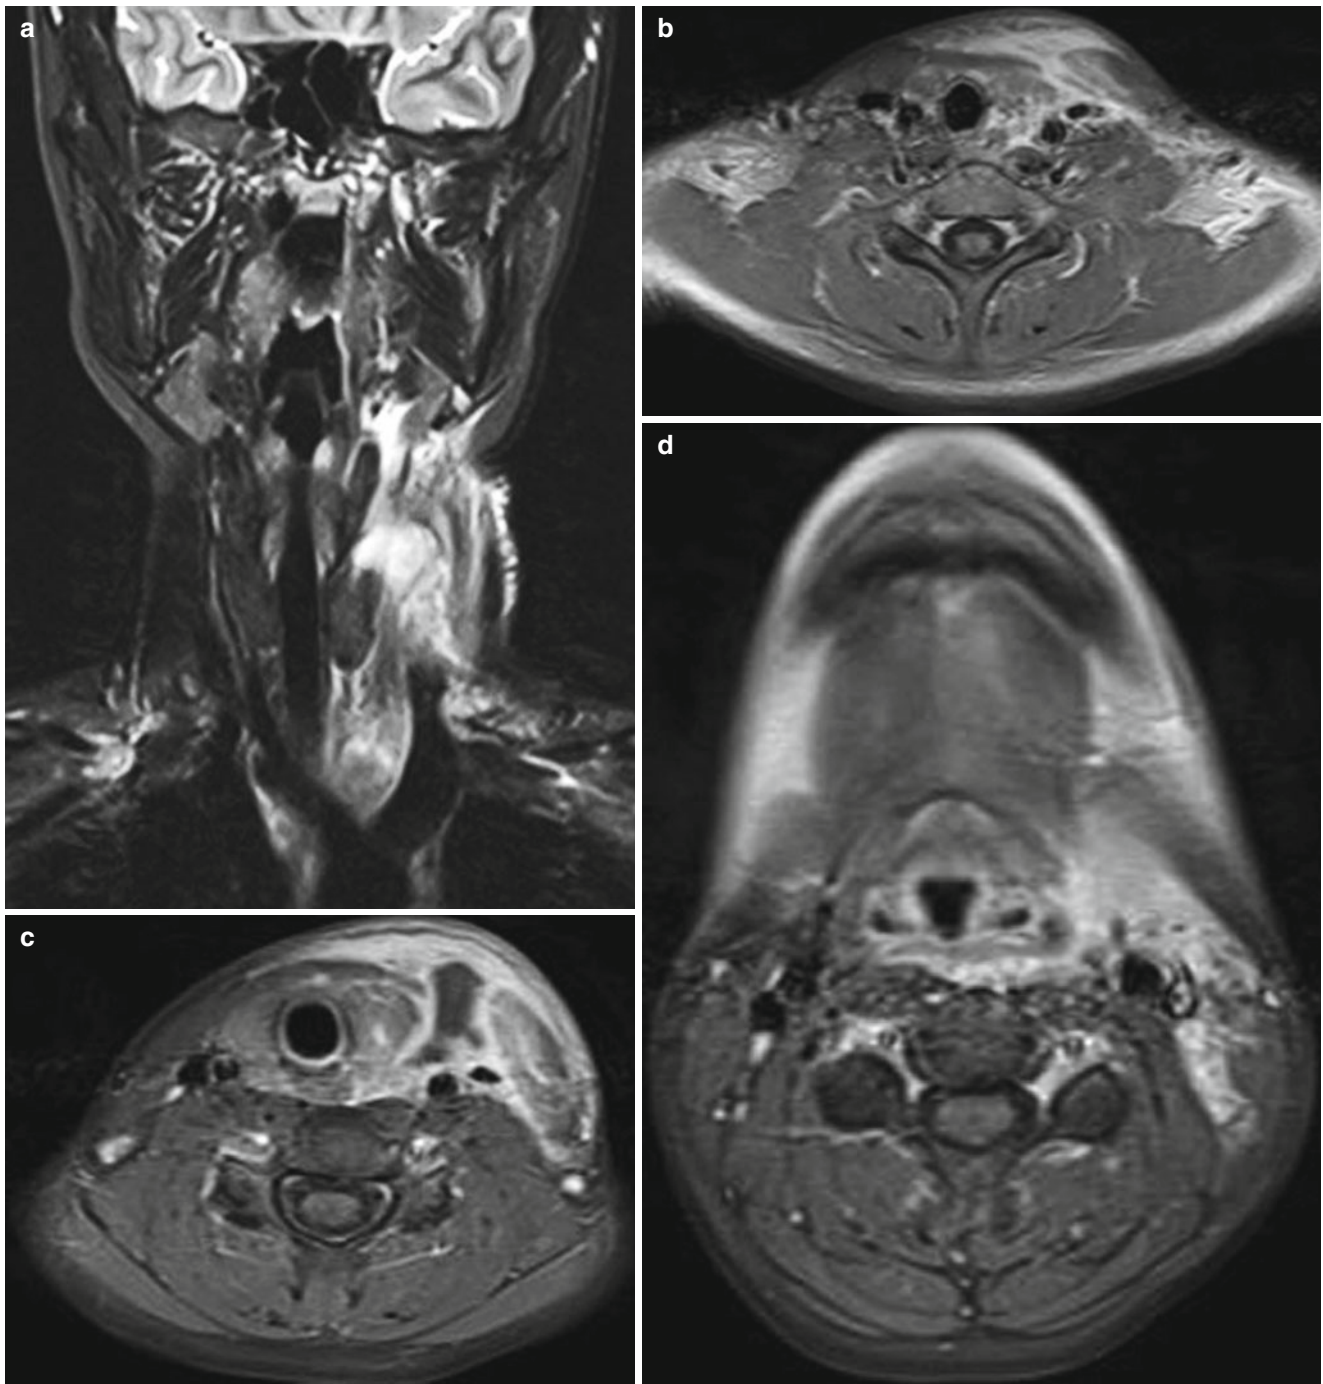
Fourth branchial cleft sinus in a 13-year-old girl with a history of recurrent swelling on the left side of the neck. (a) Coronal T2-weighted MR image shows diffuse high signal intensity of soft tissue edema from the level of the pyriform sinus to the level of the aortic arch on the left. (b–d) Contrast-enhanced axial T1-weighted
